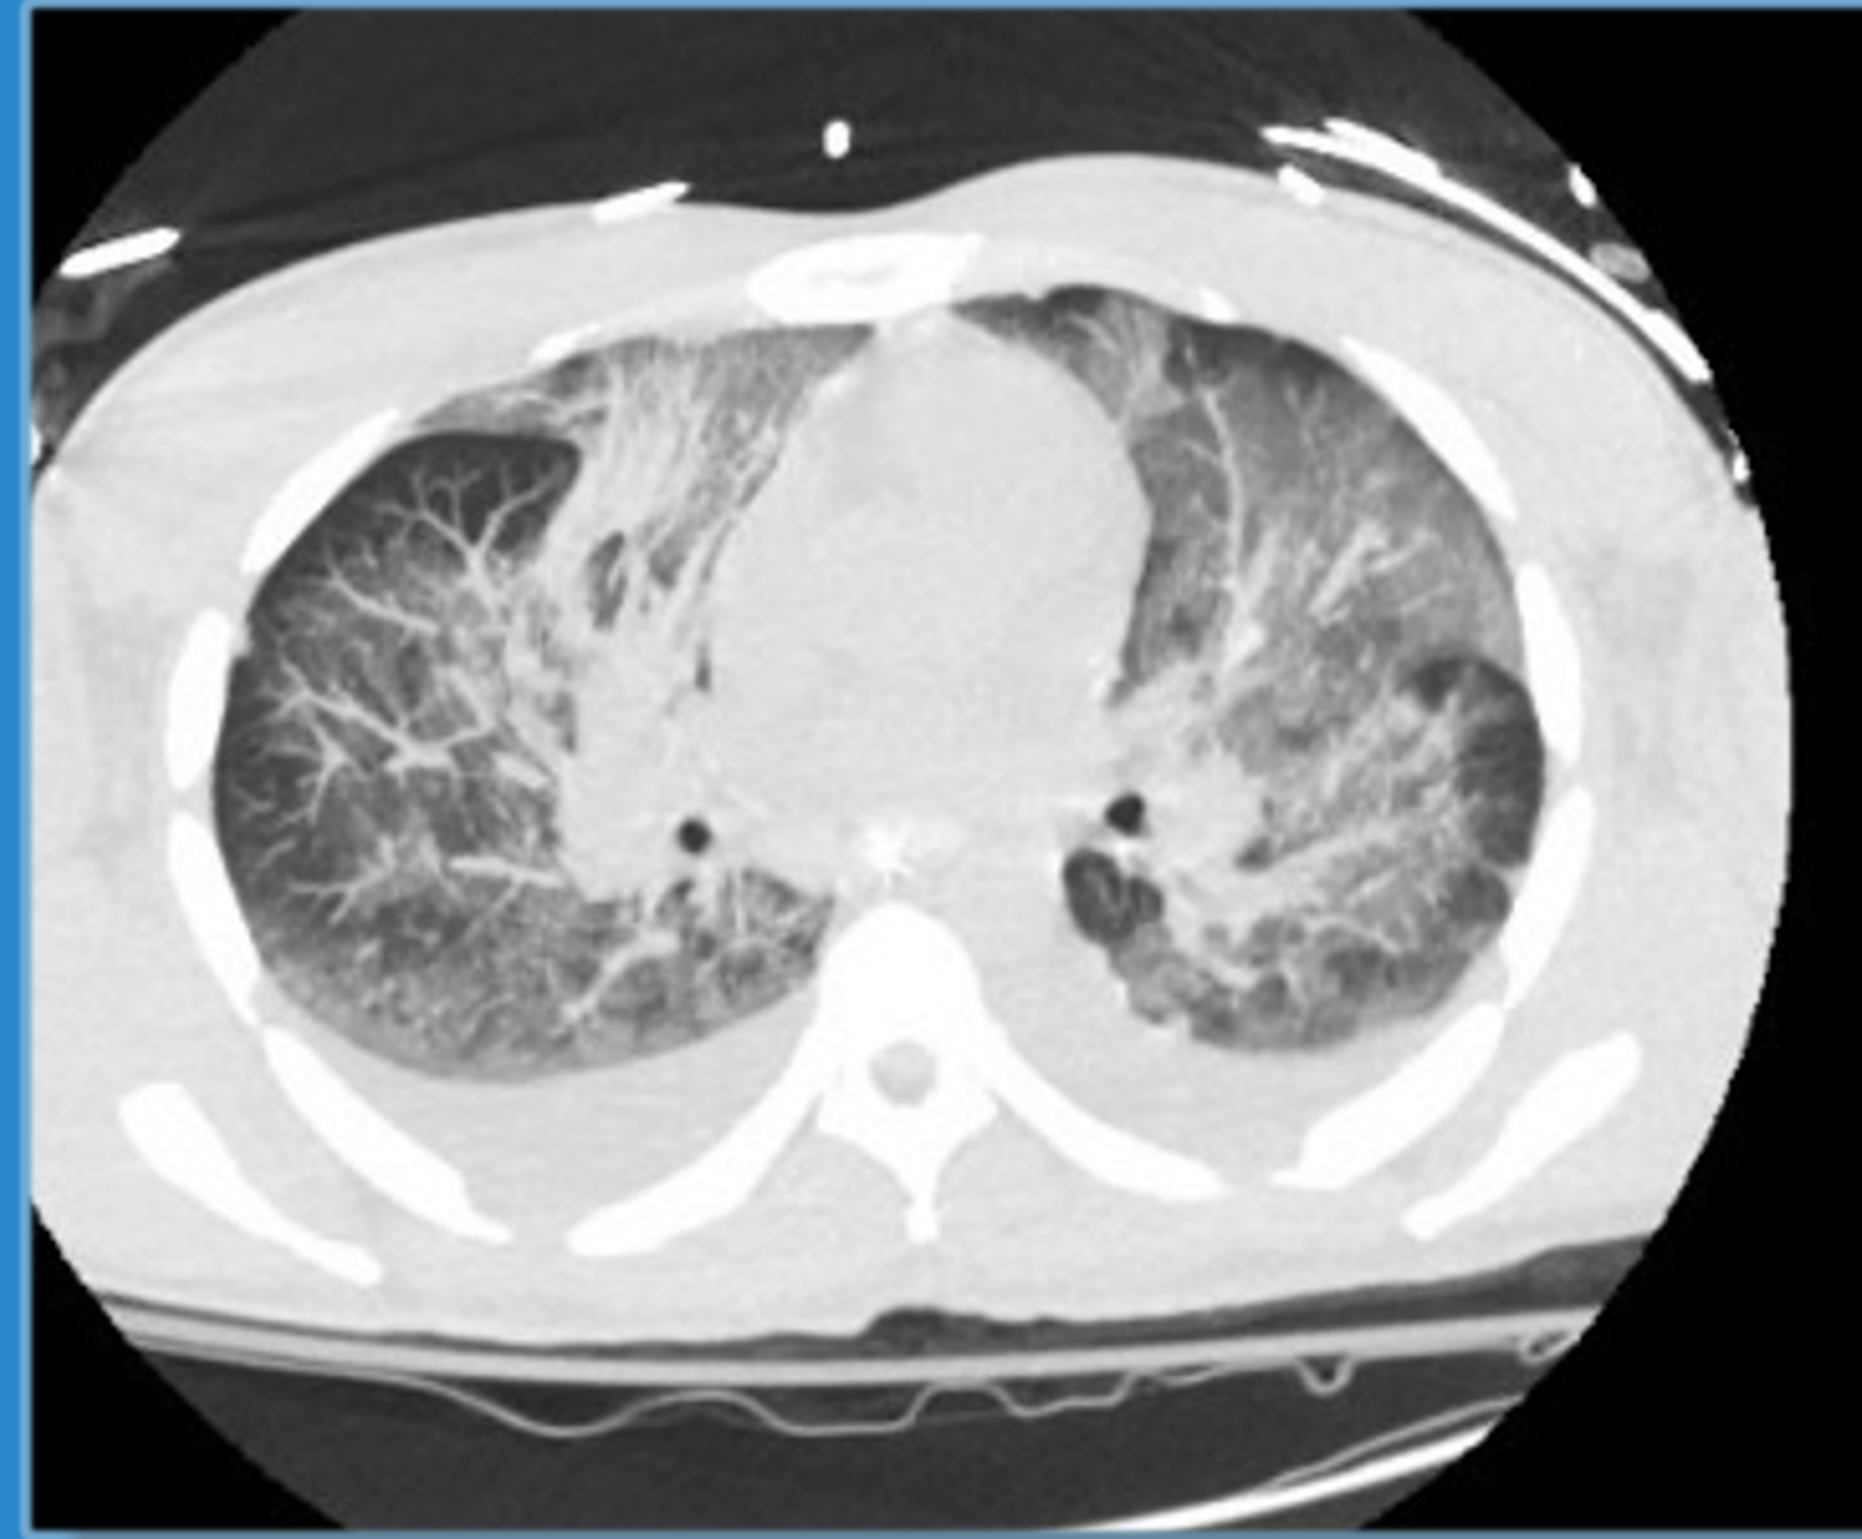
CT Chest – with contrast
